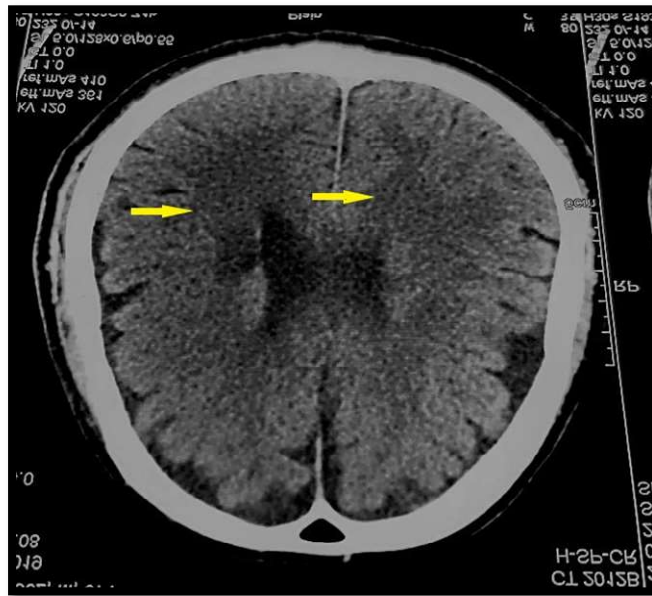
Infarcts in both Capsulo-ganglionic and para-ventricular locations (CT)
